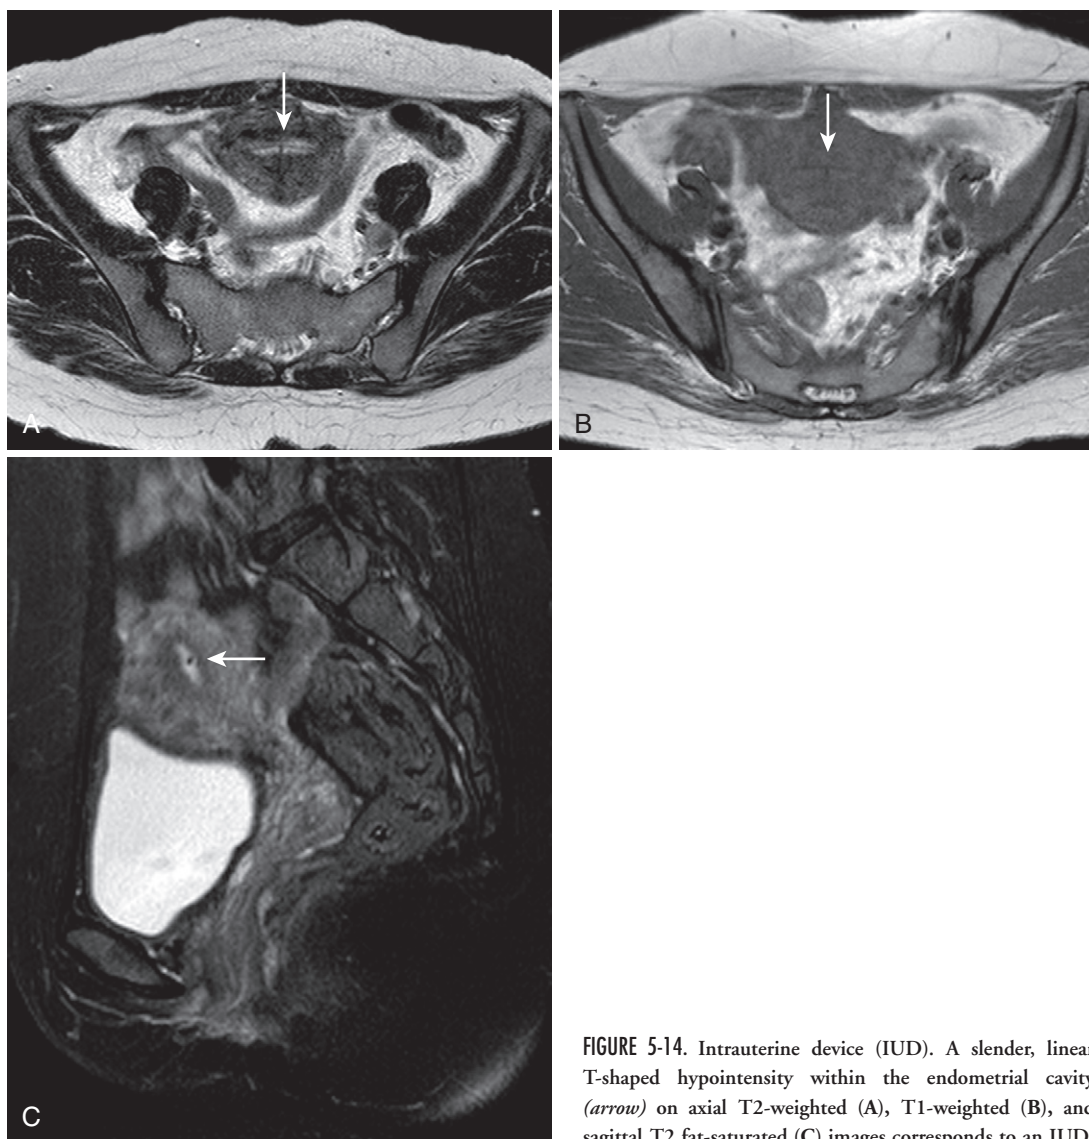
Intrauterine device (IUD). A slender, linear T-shaped hypointensity within the endometrial cavity (*arrow*) on axial T2-weighted (A), T1-weighted (B), and sagittal T2 fat-saturated (C) images corresponds to an IUD.
